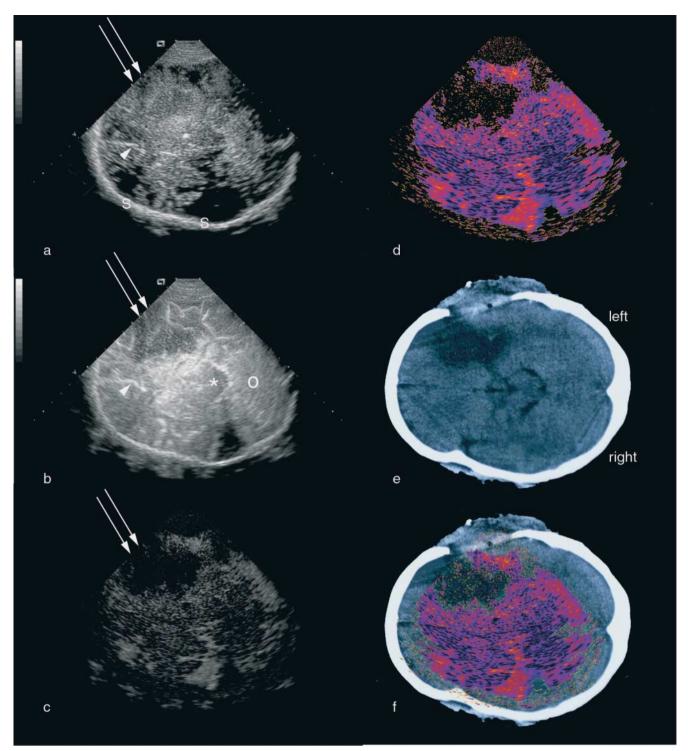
Calculation of image parameters demonstrated in the patient from Fig. 2. a shows the view of a background image (before application of the contrast agent) established by averaging 6 non-enhanced images. *Arrow:* midline shift, *two arrows:* hypoperfusion in the area of infarction. b shows the contrast enhanced B-mode image showing better delineation of the structures of the cerebral parenchyma. *Arrow:* midline shift, *two arrows:* hypoperfusion in the infarction area, *: brain stem, O: cerebellum. c shows the view of a difference-image created by subtracting the intensity of the background image from the contrast enhanced image (see text). d shows the view of the difference-image transferred in colour. e shows the CT scan showing the status following decompressive craniectomy and the area of the malignant space-occupying infarction in the left MCA territory. f shows the super-imposition of d and e demonstrating the good correspondence of the CT and ultrasound findings.
